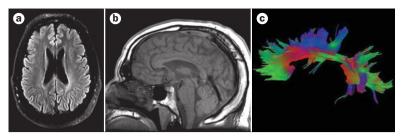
Brain imaging in a retired professional boxer with probable chronic traumatic encephalopathy. a | Axial T2-weighted brain MRI shows mild, diffuse volume loss, cavum septum pellucidum and cavum vergae. b | Saggital brain MRI demonstrates focal thinning and volume loss of the corpus collosum. c | Diffusion tensor imaging tractography reveals a focal defect and loss of white matter integrity in the corpus collosum.
